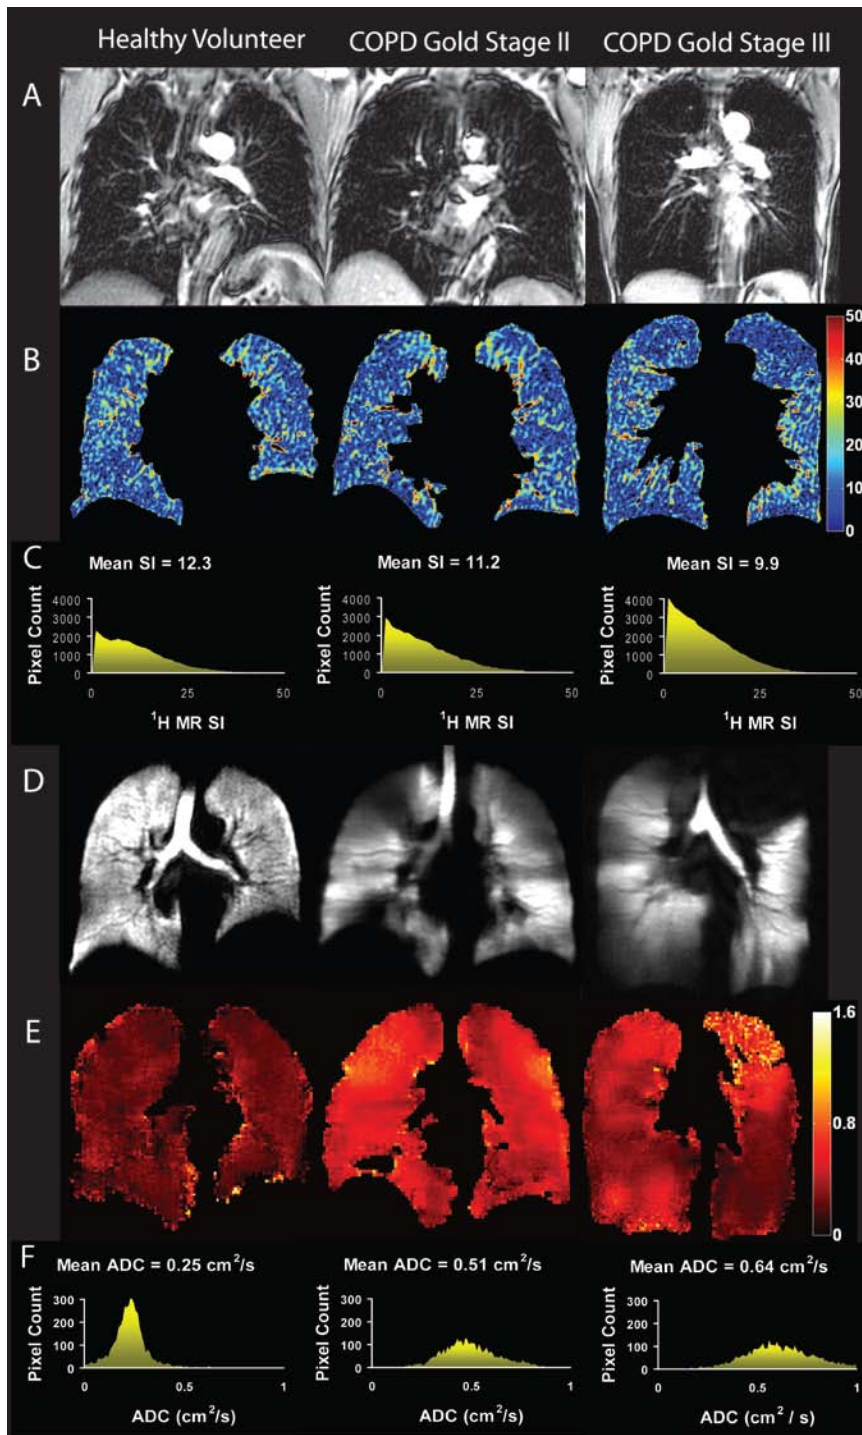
^1H and ^3He MRI for a healthy never-smoker and GOLD stage II and III COPD.
